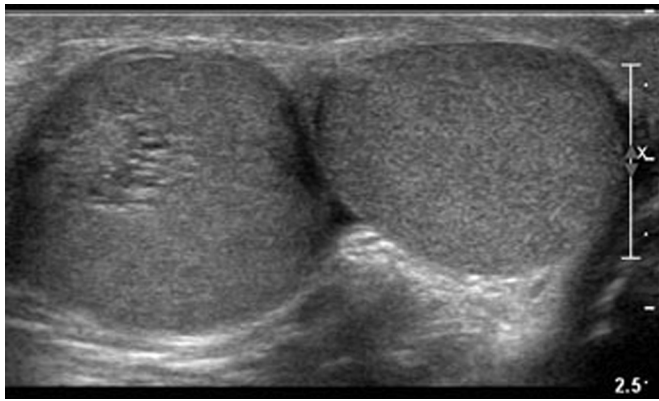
Sonogram of the scrotum demonstrate double testicles in the left hemiscrotum and tubular ectasia of the rete testis in superior testicle.
